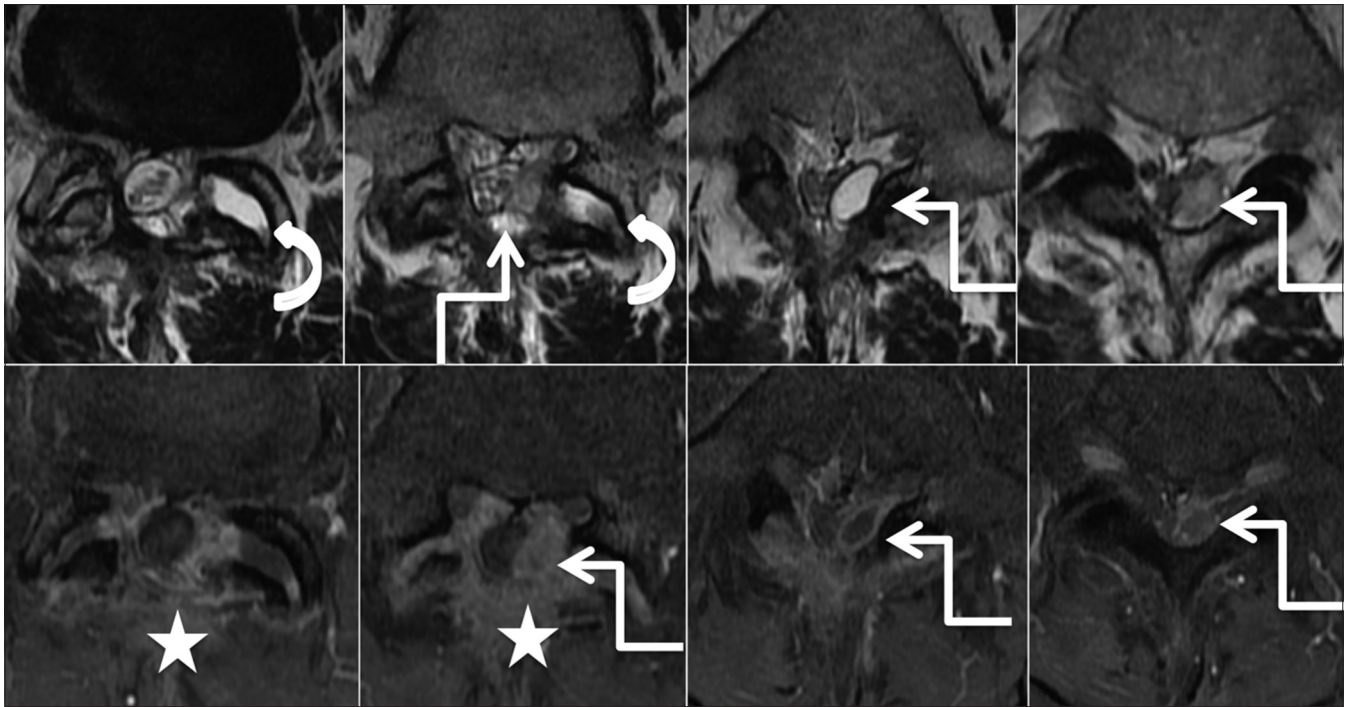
Degenerative: Synovial cyst: Postoperative scan: Axial T2-weighted (upper row) and post-contrast T1 fat saturated (lower row) images from superior to inferior aspect, show laminectomy defect with postoperative changes in the paraspinal region (star). Fluid in left L4-5 facet joint (curved arrow) appears to communicate with the lobulated cystic lesion showing rim enhancement in the left posterior epidural space. [Courtesy: Dr Vipul Chemburkar]
